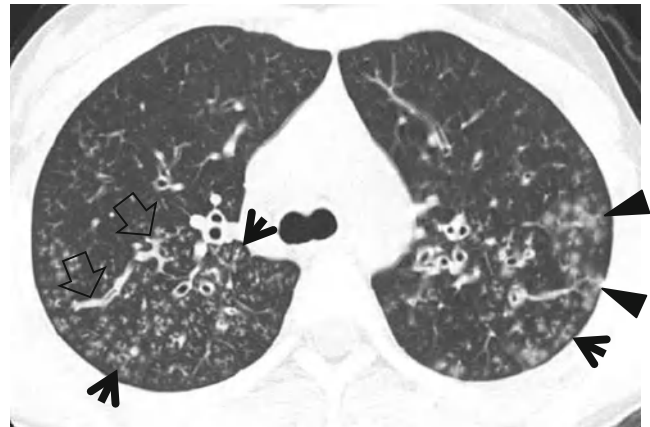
Cystic fibrosis in a 21-year-old woman. Lung window image of CT scan (2.5-mm section thickness) obtained at level of azygos arch shows well-defined (arrows) and poorly defined (arrowheads) tree-in-bud sign in both upper lobes. Also note mucus plugging (open arrows) in medium-sized airways
